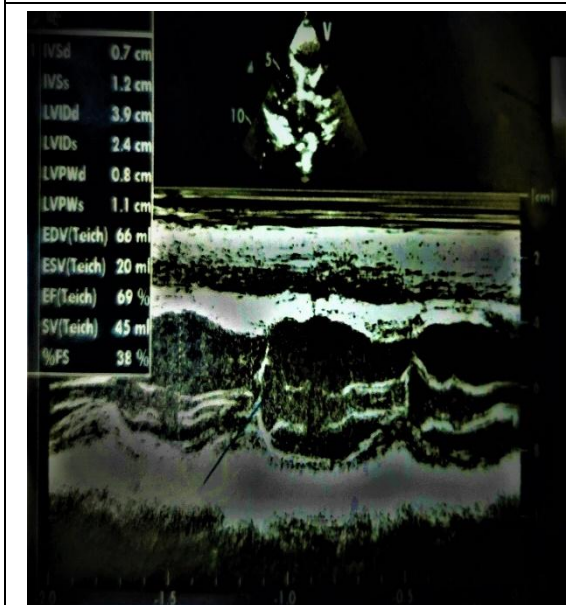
Echocardiograph showing fair biventricular systolic functions (ejection fraction, EF- 69%).
